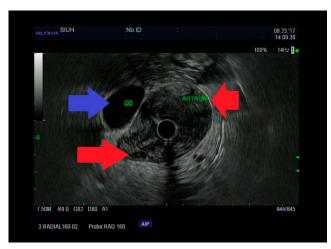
Endoscopic ultrasound image showing a hemicircumferential mass of 3.5×4.5 cm (blue arrow) and antrum submucosa (red arrows).
